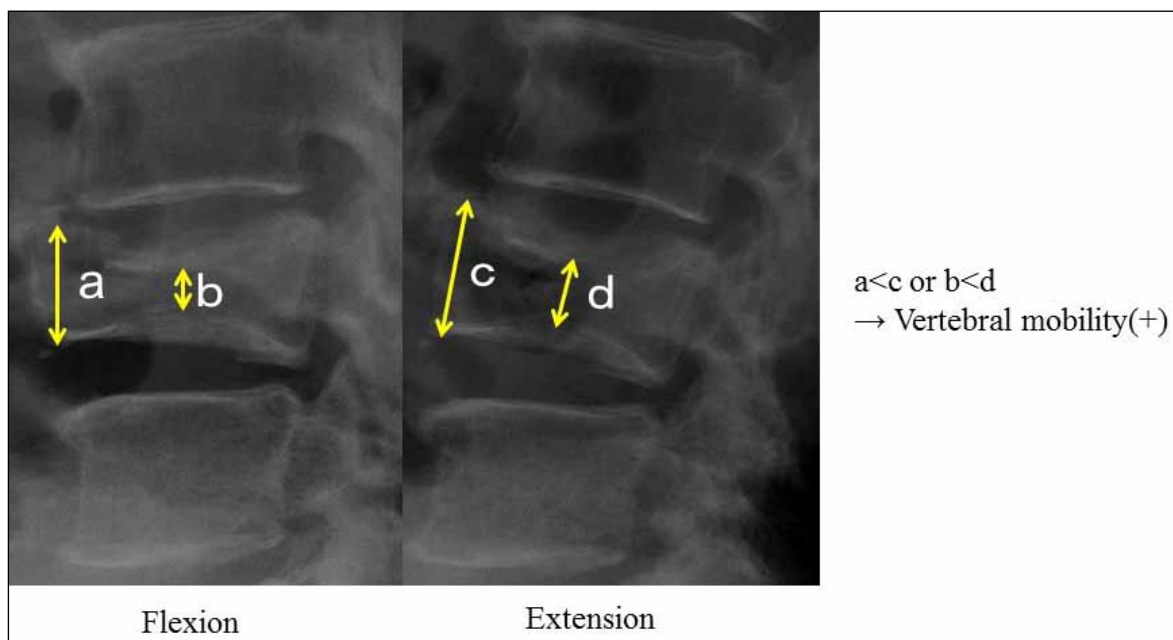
Preoperative lateral radiographs of a patient with VCF with vertebral instability. The collapsed vertebral body shows dynamic mobility. The vertebral height increased with extension stress.
